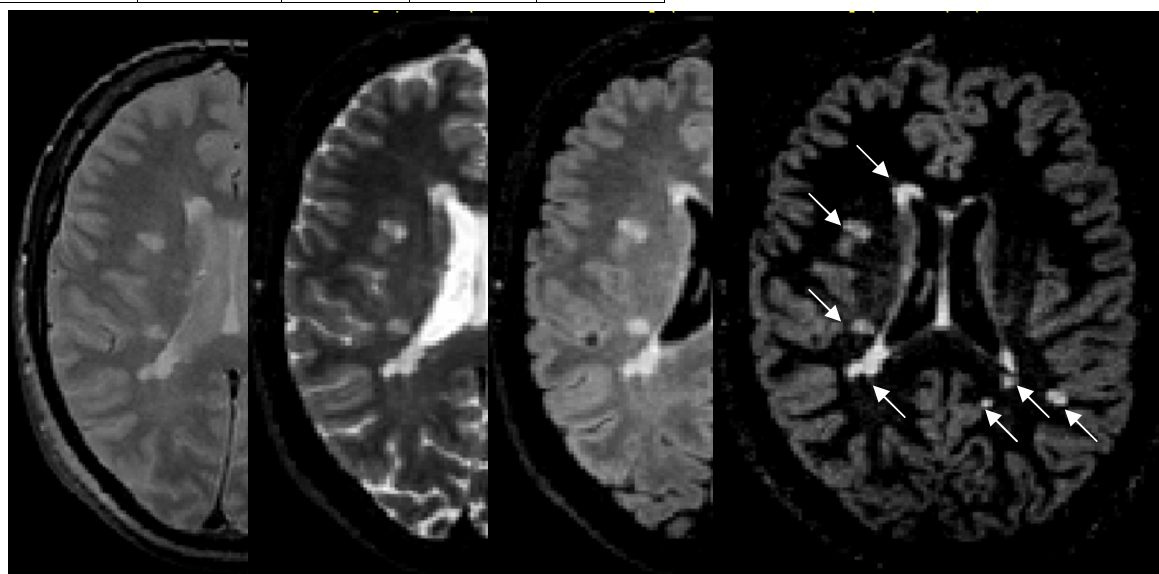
From left to right the 2D-T2SE, 3D-T2, 3D-FLAIR and 3D-DIR images, as analyzed in this study. Note the high contrast between lesions and CSF in the FLAIR image, and the high contrast between lesions and both CSF and WM in the DIR images. Images show various periventricular and deep WM lesions.
